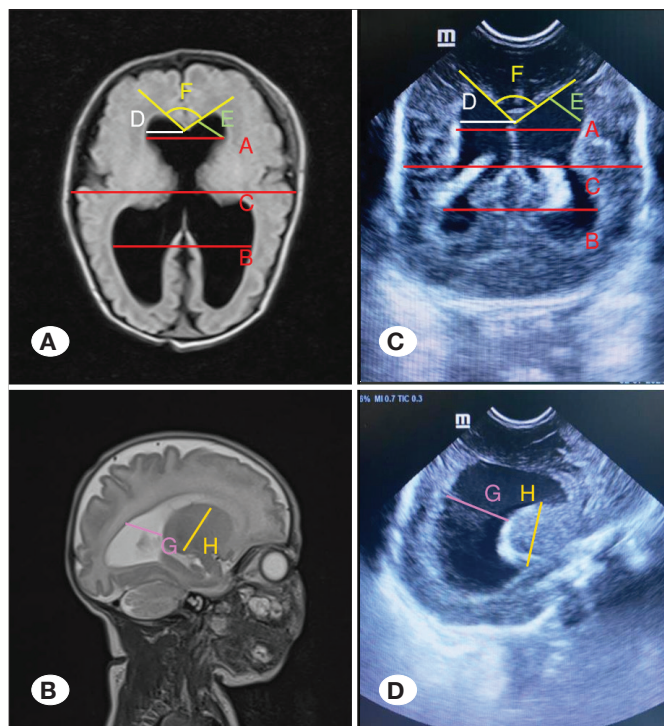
Representative images for MRI (A,B) and TFUS (C,D) measurements. Evans index=A/B; FOHR=A+B/2C; bilateral ventricular index=D; bilateral anterior horn width=E; callosal angle=F; bilateral thalamooccipital distance=G; corpus callosum length=H.
